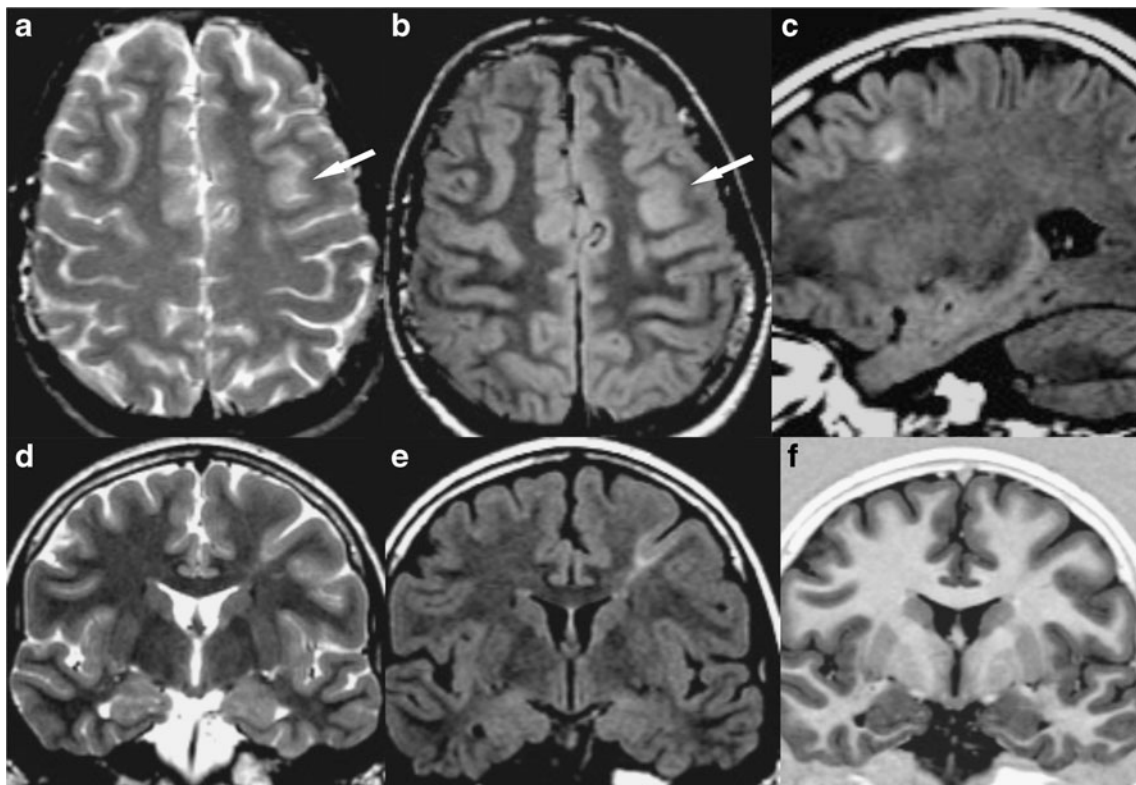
FCD IIb: a axial TSE-T2WI, b axial FLAIR-T2WI; c sagittal FLAIR-T2WI, d, e, f coronal TSE-T2WI, FLAIR-T2WI and IR-T1WI. In the left frontal lobe, a very tiny dysplasia is recognized at the bottom of an abnormally deep sulcus, where the cortex appears thickened on axial images (a, b) (*white arrows*). On coronal images the transmantle
